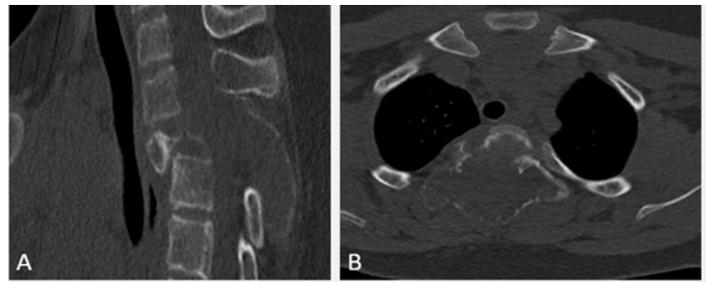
Preoperative CT scan showing the lesion (A) sagittal CT of the spine (bone window), (B) axial CT scan (bone window).
